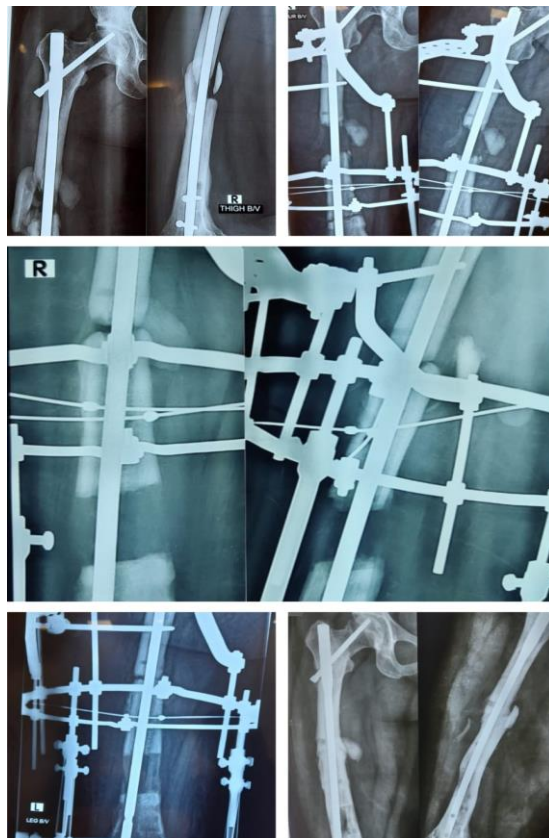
Radiographs of a 40 years old female patient showing femoral fracture before operation, after Proximal Femoral nail application and Ilizarov frame construction
